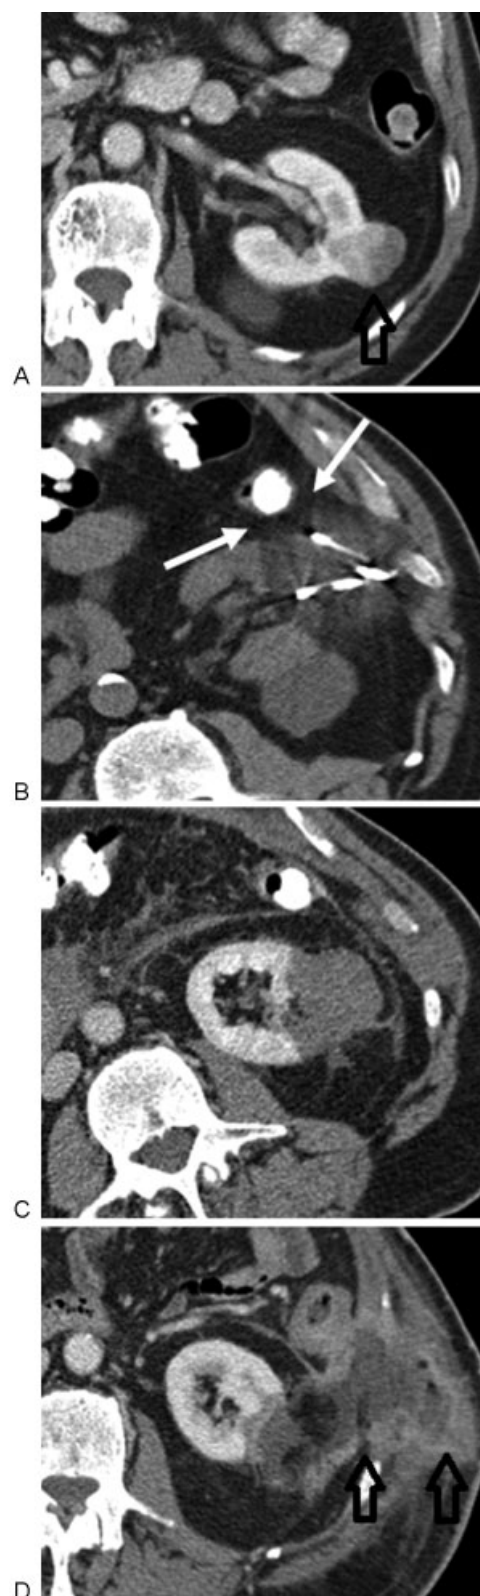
Abscess due to bowel perforation. (A) CT shows a 3.2-cm mass in the left mid kidney (arrow) in an 81-year-old man. (B) CT during cryoablation shows the ice ball (arrows) to encroach upon the descending colon. (C) CT immediately postablation shows complete ablation of the mass. (D) CT performed 2 months later shows a large abscess in the left retroperitoneum and chest wall (arrows), communicating with the ablation zone, presumably related to colonic perforation. CT, computed tomography.
